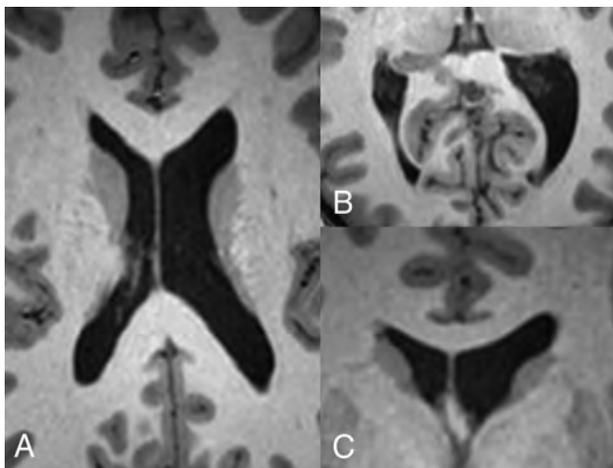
Variations in lateral ventricular size and shape in a healthy 16-year-old girl. Axial T1-weighted MR images through the bodies of the lateral ventricles (A) and occipital horns (B) demonstrate a larger left lateral ventricle. Note the differences in morphology of the occipital horns. C, Coronal T1-weighted MR image through the frontal horns demonstrates relative enlargement of the left lateral ventricle.
